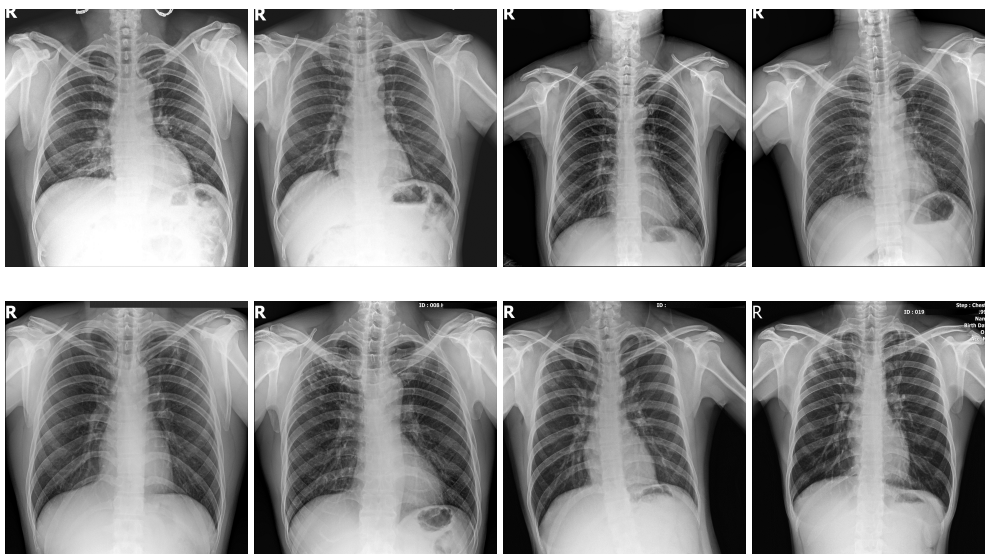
Some samples of the normal (top line) and abnormal (bottom line) images from our X-ray ChestVN dataset.
